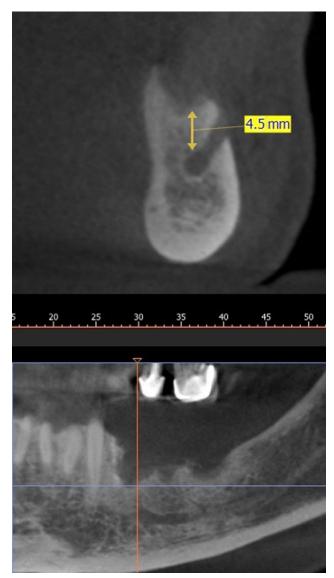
Preoperative CBCT. At the lowest point, only 4.5 mm of bone remained above the mental foramen.
